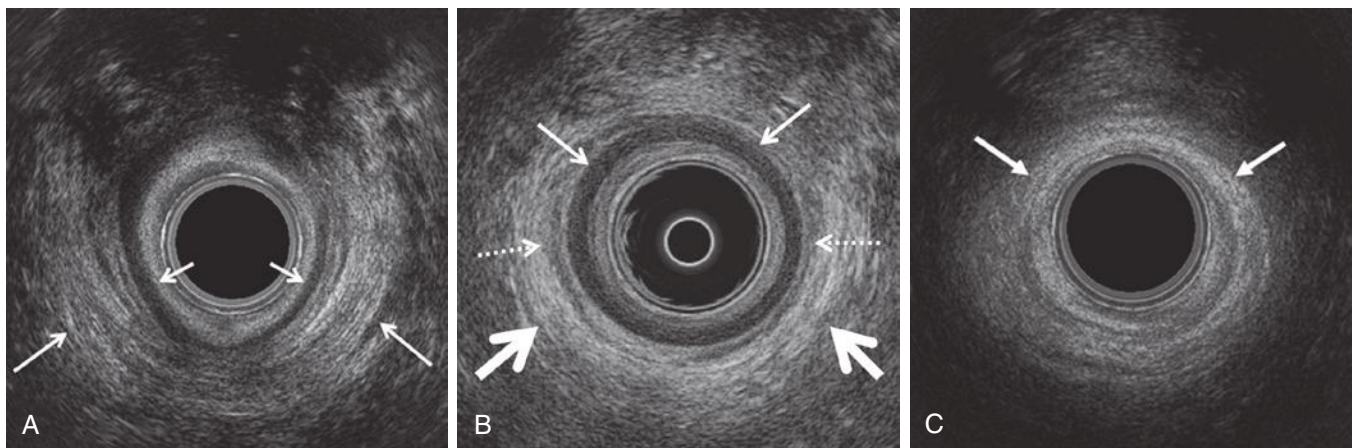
Transverse ultrasound images of the normal anal sphincter. Endoanal ultrasound images at three levels (upper sphincter, midsphincter, and caudal sphincter) at the level of the puborectalis muscle (PRM) shows the internal sphincter, intersphincteric fat, and external sphincter as separate structures. A, Endoanal ultrasound image: transverse image of the cephalad (upper) anal sphincter demonstrating the striated relatively echogenic U-shaped sling of the posterior PRM (*long arrows*) and the hypoechoic internal anal sphincter (IAS) (*short arrows*). Note that at this level the external anal sphincter (EAS) is absent. The innermost echogenic ring represents the rectal mucosa and interface with the transducer (central round black structure). B, Normal appearance on endoanal ultrasound of the anal sphincters at the midsphincteric level demonstrating the characteristic target or layered appearance. The inner echogenic ring represents the mucosa and interface with the transducer, the IAS is the subjacent markedly hypoechoic ring (*thin arrows*) and the outermost ring represents the EAS (*thick arrows*) and is typically either hyperechoic or of mixed echogenicity. Wispy hypoechoic curvilinear strands with a striated appearance (*dotted arrows*) between the IAS and EAS represent the longitudinal muscle layer. C, Endoanal ultrasound image: transverse image of the normal caudal or distal anal sphincter image where the echogenic EAS (*arrows*) extends beyond the IAS representing the superficial portion of the EAS.
